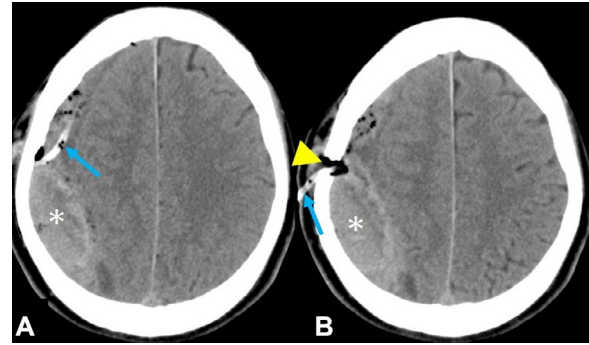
Contiguous images of axial computed tomography scans performed immediately after burr-hole irrigation, at the same levels in Fig. 1, showing the presence of biconvex hemorrhage in the right parietal convexity (asterisk). The center of the epidural hemorrhage is located 3.5 cm posterior to the posterior margin of the burr-hole (arrowhead). Arrow: subdural drain tube.
